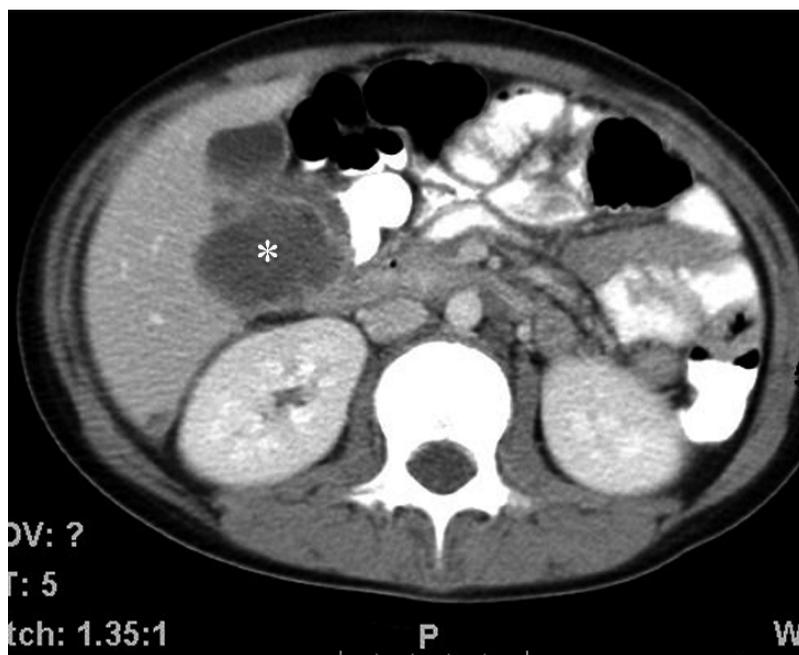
CT scan of a febrile patient after surgery for ruptured appendicitis shows an abscess (*) near the gallbladder fossa.
